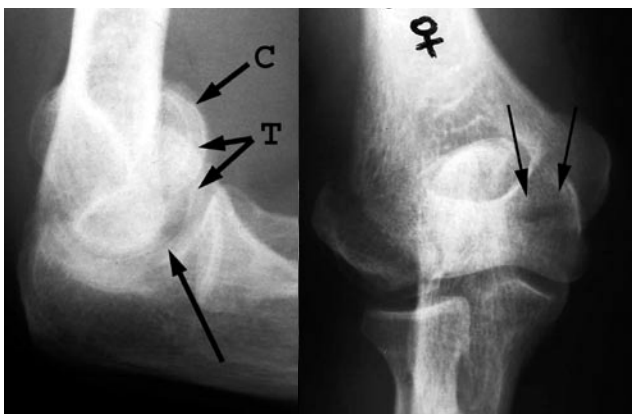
Preoperative lateral (left) and anteroposterior (AP; right) x-rays of the patient's right elbow. Note in the lateral view the nonconcentric arcs of the capitellum (C) and the trochlea (T) and the void at the inferior aspect of the ulnohumeral and the radio-capitellar joints (arrow). In the AP view, the capitellum is markedly displaced and externally rotated. Also note the pathognomonic radiographic finding suggesting the trochlear fracture on the AP view—presence of a fracture line medial to the midline of the joint and distal to the medial epicondyle (arrows).
